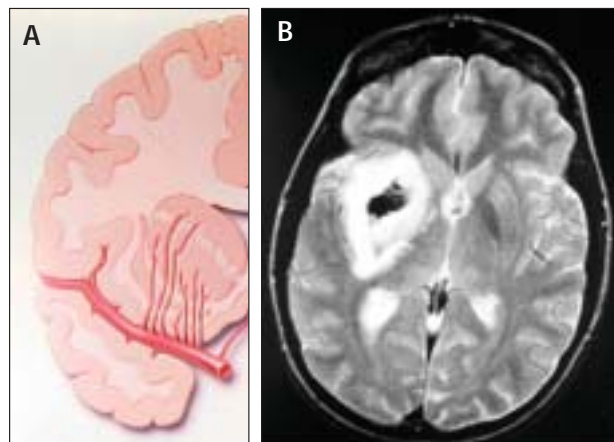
A coronal section of the right hemisphere at the level of sylvian fissure and caudate and putamen (A). The MCA is seen sending lenticulostriate arteries to the deep nuclei. MRI axial section demonstrating increased signal intensity in the right (pictured on the left side of the image) and deep nuclear infarction after M1 occlusion with successful recanalization 4 hours from onset of symptoms (B).
